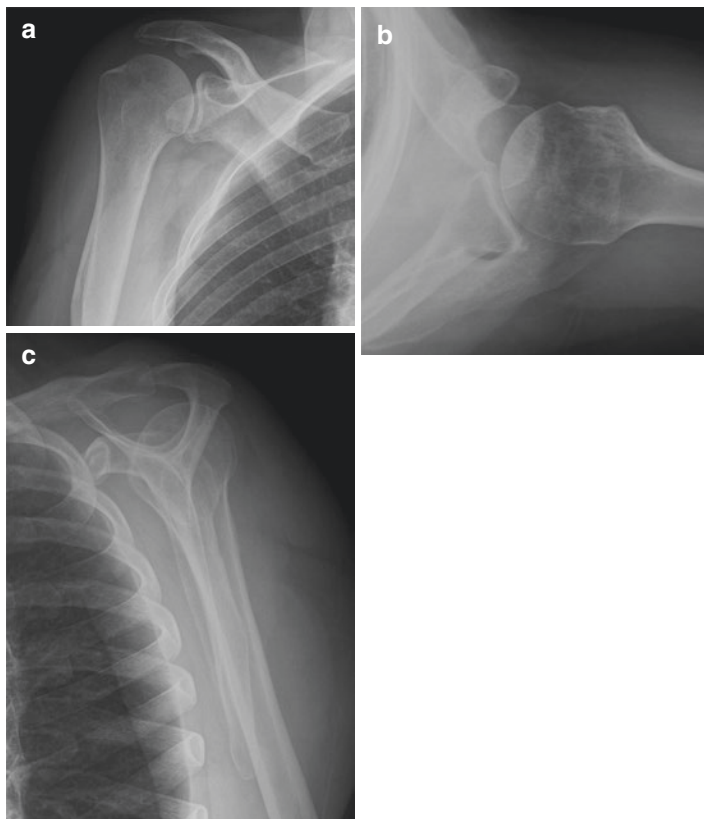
Plain radiographs of the shoulder revealed mild degenerative changes of the AC joint and preserved glenohumeral joint space. (a) Grashey view, (b) axillary view, (c) scapular Y view
